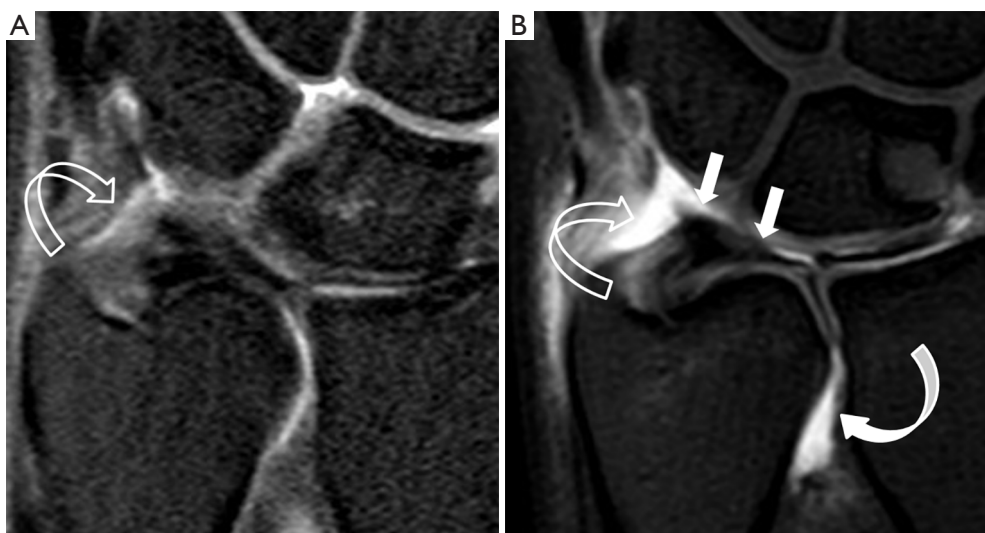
Comparison of TFCC visualization by non-arthrogram MRI (A) and MR arthrogram (B). Before injection of contrast, the prestyloid recess (block curved arrow) is not distended and the radiocarpal joint surface of TFCC cannot be well delineated. After contrast injection into the joint, the joints are well distended including the prestyloid recess (block curved arrow) and DRUJ (solid curved arrow). The surface of the TFCC can now be well delineated (solid arrows). TFCC, triangular fibrocartilage complex; DRUJ, distal radioulnar joint.
